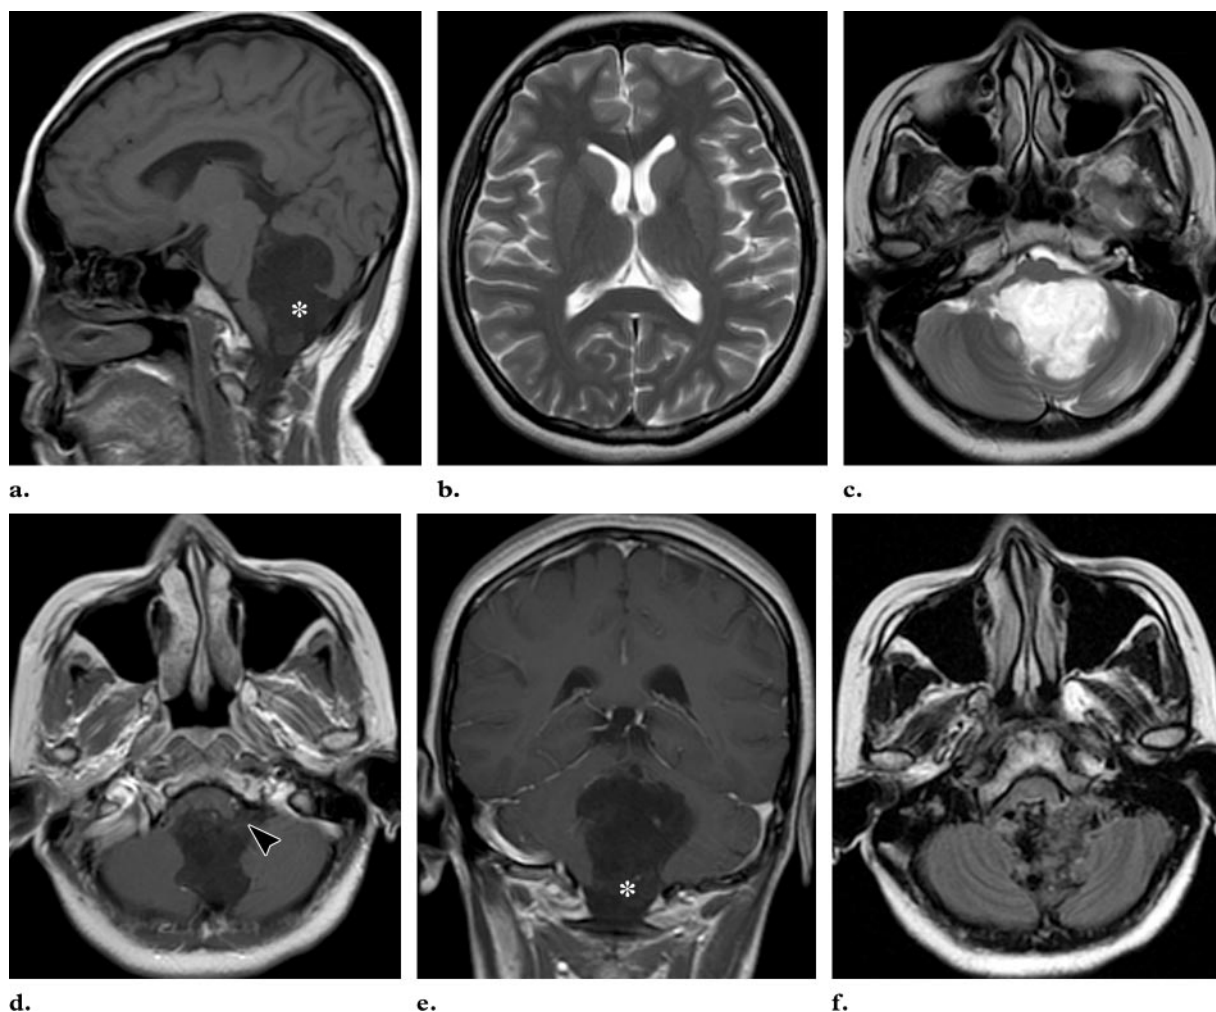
Epidermoid tumor depicted on sagittal T1-weighted (a), axial T2-weighted (b, c), axial (d) and coronal (e) gadolinium-enhanced T1-weighted, and axial fluid-attenuated inversion recovery (FLAIR) (f) images. A fourth ventricle mass is seen expanding, distorting, and compressing the brainstem without any evidence of obstructive hydrocephalus, as demonstrated by the normal size of the lateral ventricles superiorly (b). The mass insinuates through the foramen of Magendie (* in a and e) and the foramina of Luschka (best seen on the left in c, d, f; arrowhead in d) and extends into the cisterna magna and caudally to the level of the foramen magnum (a). On T1-weighted images (a, d, e), its signal is only slightly hyperintense relative to cerebrospinal fluid (CSF). On T2-weighted images (b, c), the mass has a hyperintense but heterogeneous signal, unlike the homogeneously high signal intensity of CSF. No significant enhancement is seen, and there is clear failure of suppression of signal on the FLAIR image. This appearance is characteristic of an epidermoid tumor.
